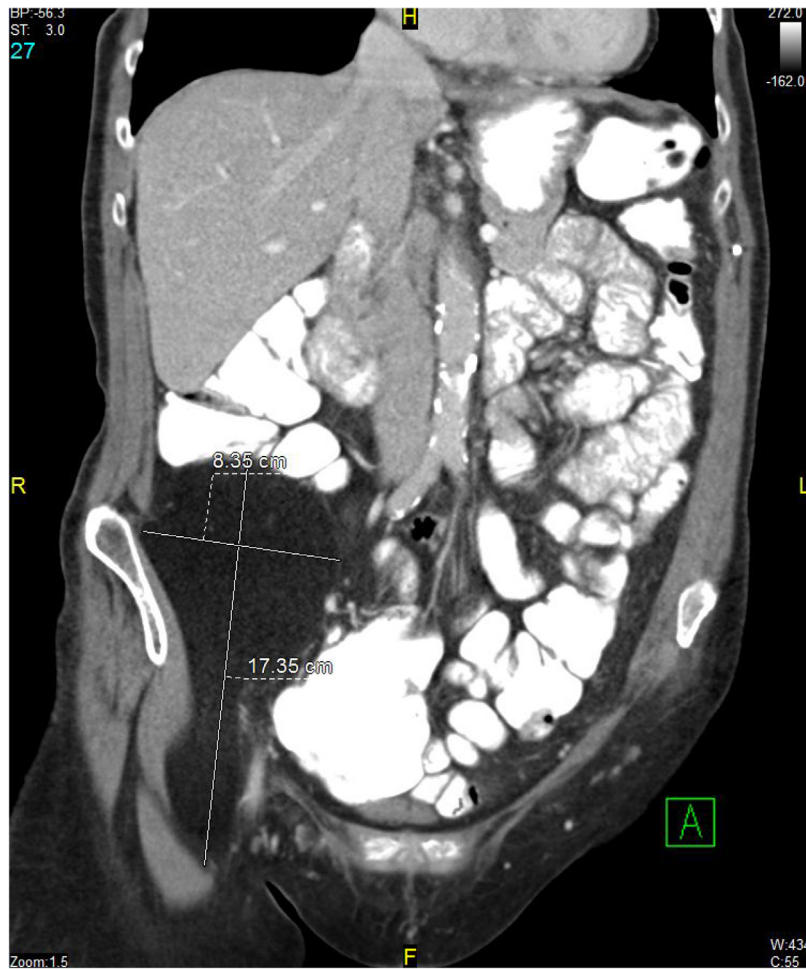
Initial CT imaging of the mass, showing extension of the caudal tail into and through the inguinal canal.
